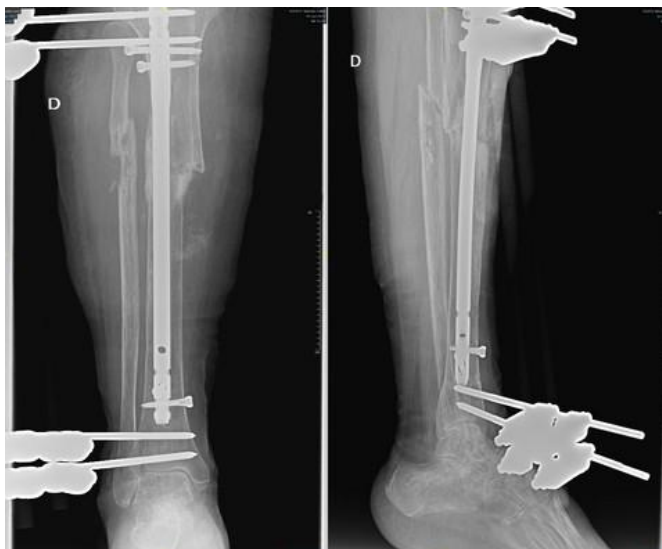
X-Ray 2 Weeks After Second Surgery
